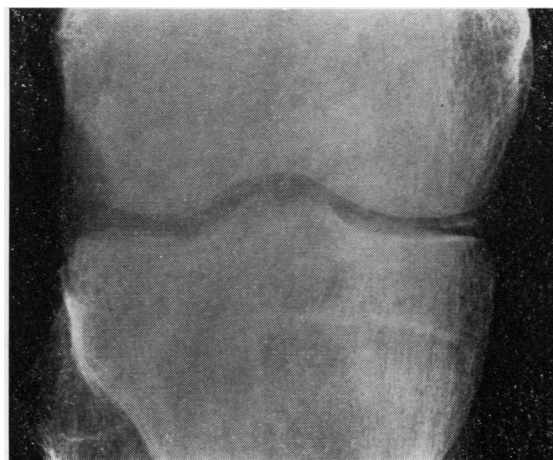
Case 2. Radiograph of right knee showing clear evidence of chondrocalcinosis.
